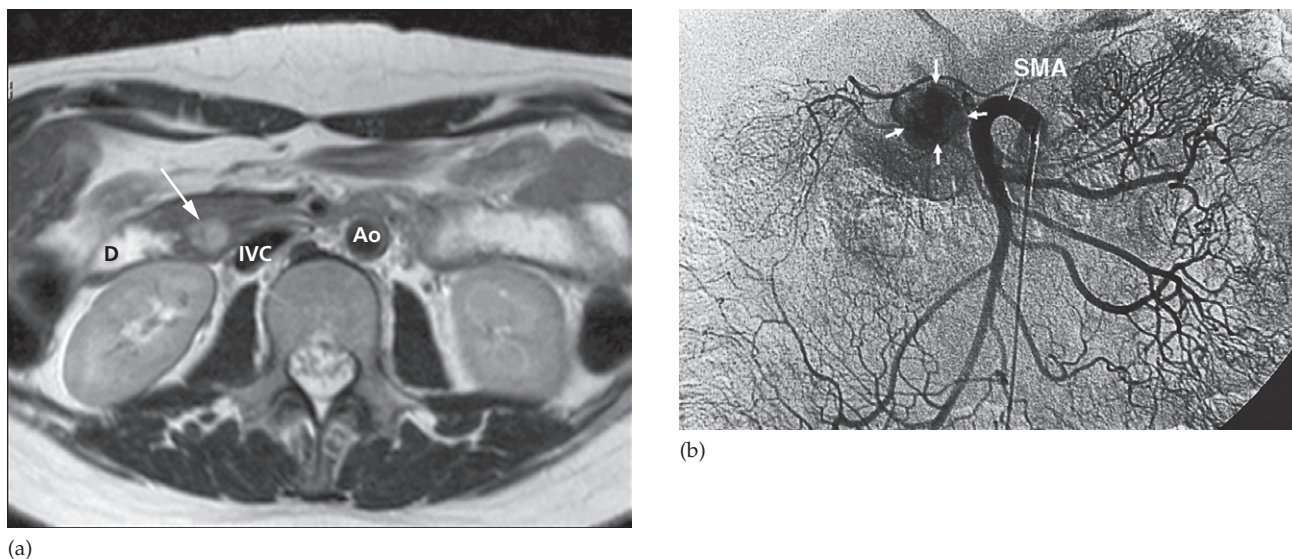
Insulinoma. (a) Axial T2-weighted MRI demonstrating a 1.5 cm insulinoma in the uncinate process of the pancreas (arrow). (b) Selective superior mesenteric angiogram in another patient showing the tumour as a vascular blush (arrows). Ao, aorta; D, duodenum; IVC, inferior vena cava; SMA, superior mesenteric artery.
